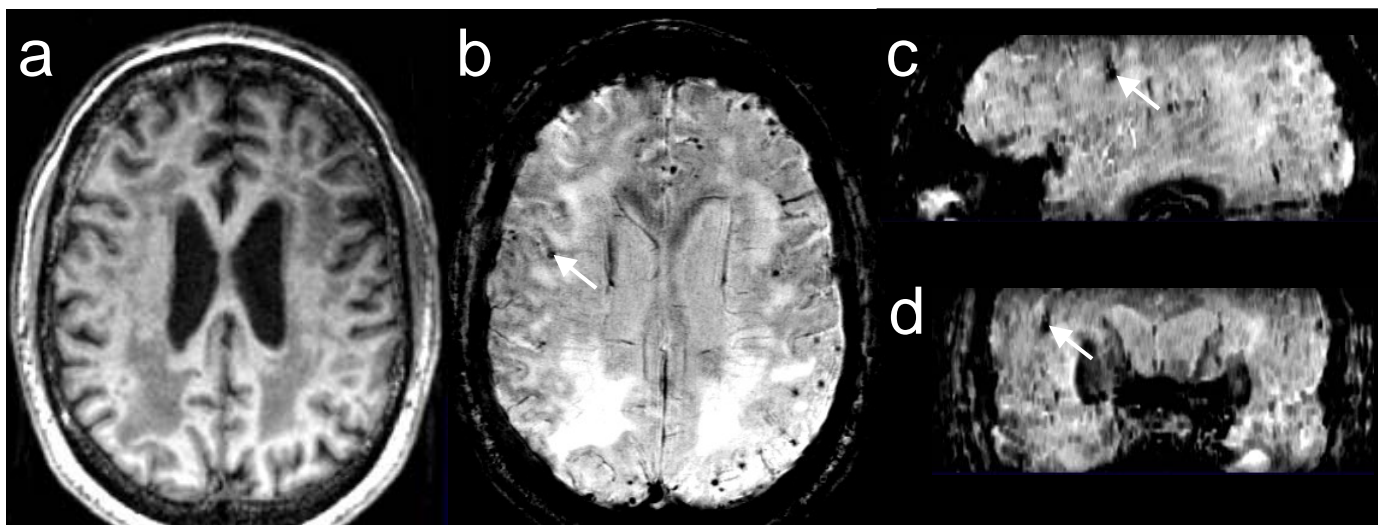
Structural MR image (a) and susceptibility-weighted MR images (b-d), representing three orthogonal sections through a hemorrhagic lesion (arrows), acquired at 4 Tesla from a patient suffering from cerebral amyloid angiopathy.
